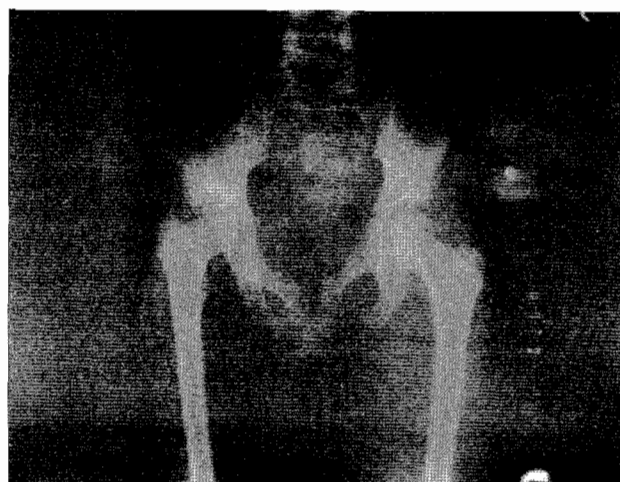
X-rays of the pelvis showing septic arthritis of right hip with narrowing of the right hip joint space.
